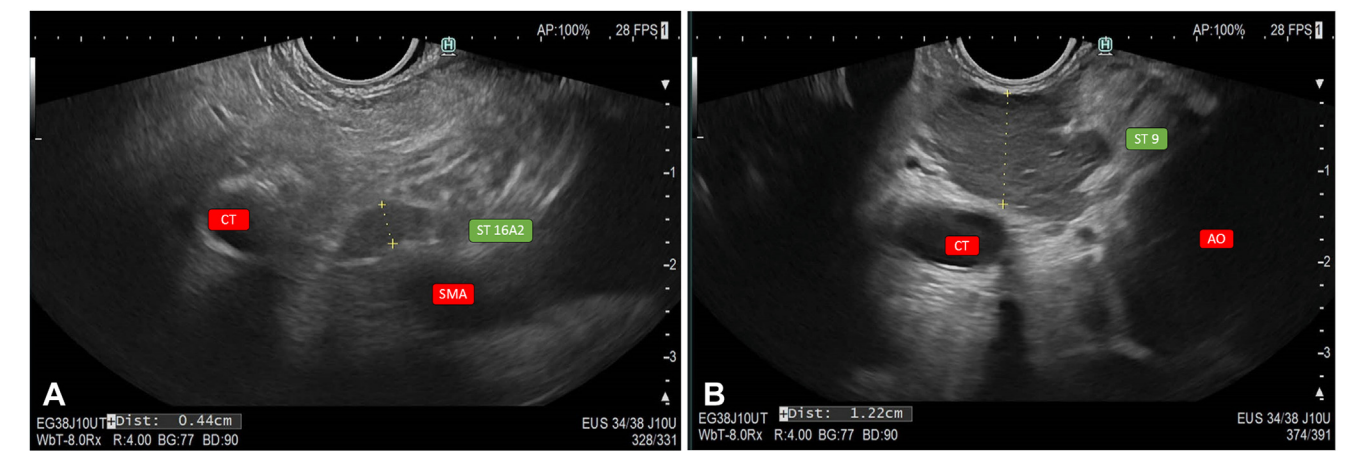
Two examples of identified LNs. A, An unsuspicious LN located at station 16A2. A biopsy was not performed. B, A suspicious LN located at station 9. Biopsy showed malignancy. AO, Aorta; CT, celiac trunk; SMA, superior mesenteric artery; ST, station.
